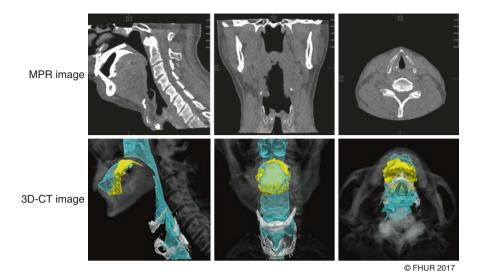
MPR and 3D-CT images. (*Upper row*) MPR images: sagittal, coronal, and axial planes. (*Lower row*) 3D-CT images: lateral, posterior, and inferior views (the vocal cords can be visualized)
